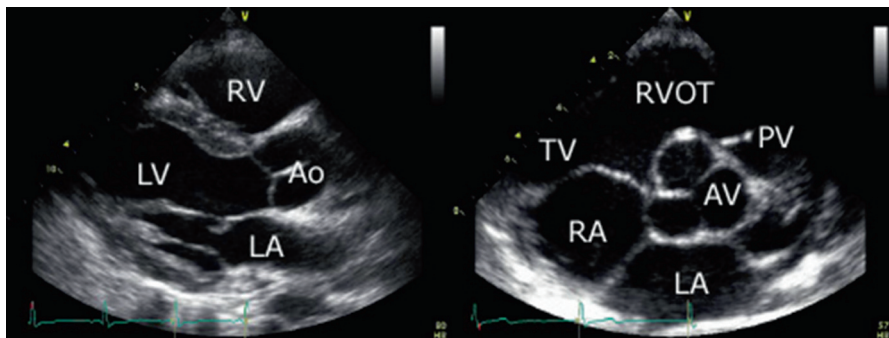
Parasternal long-axis section through the aortic root (*left panel*) shows the closed aortic valve, while the short-axis section shows all three leaflets of the valve. *Ao* aorta; *LA* left atrium; *LV* left ventricle; *RA* right atrium; *RV* right ventricle; *RVOT* right ventricular outflow tract; *PV* pulmonary valve; *TV* tricuspid valve
